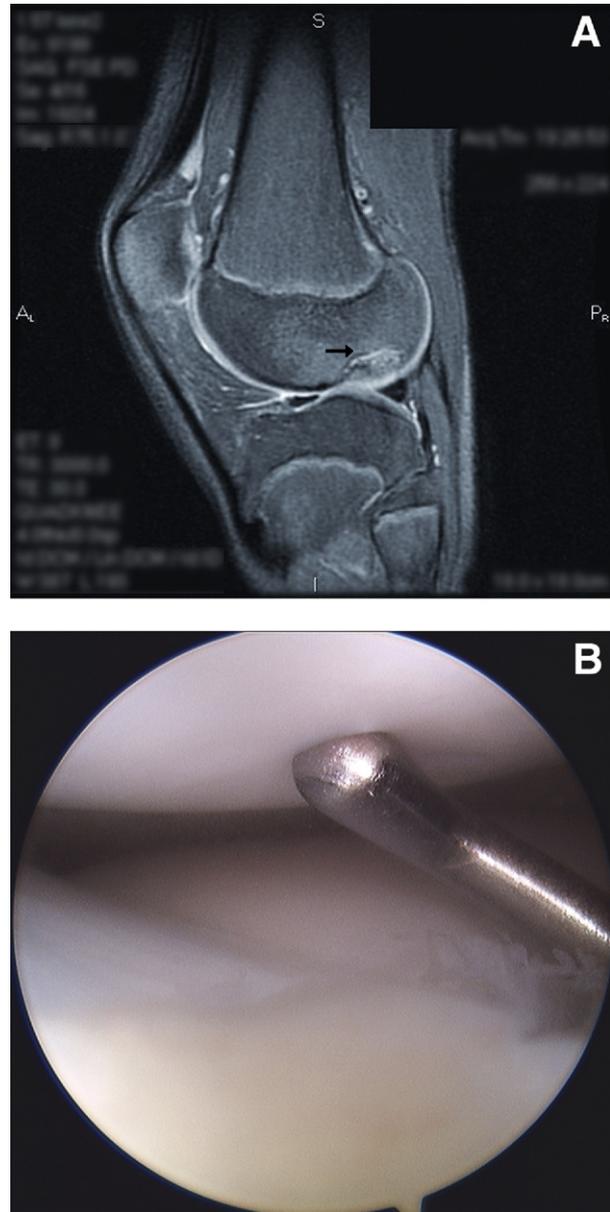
MRI instability: false positive. An unstable lesion on MRI was found to be stable with intact cartilage on arthroscopy. (A) Fast spin-echo proton density-weighted sagittal MR image through an OCD lesion in the lateral femoral condyle. The patient presented with knee pain after an injury that persisted despite 8 months of conservative management. Note the thin line of high signal intensity (arrow) at the interface between the lesion and the underlying bone. The radiologist interpreted this lesion as unstable, based on criterion 1. (B) The same lateral femoral condyle OCD lesion shown arthroscopically through the anteromedial portal in the patient’s left knee. Softening of the cartilage confirmed the presence of the underlying lesion, but the cartilage was completely intact and the lesion was stable.
